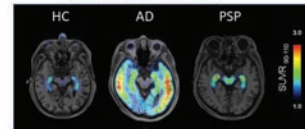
Typical SUVR images
